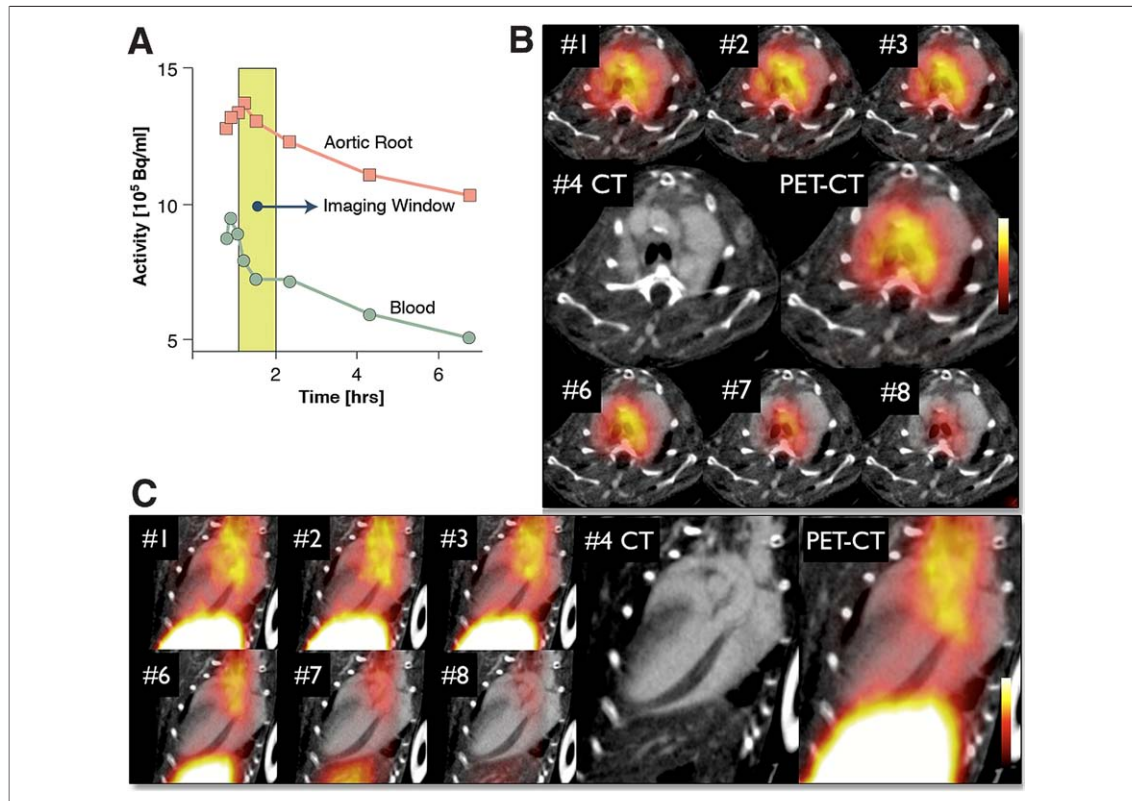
Dynamic PET-CT Imaging
